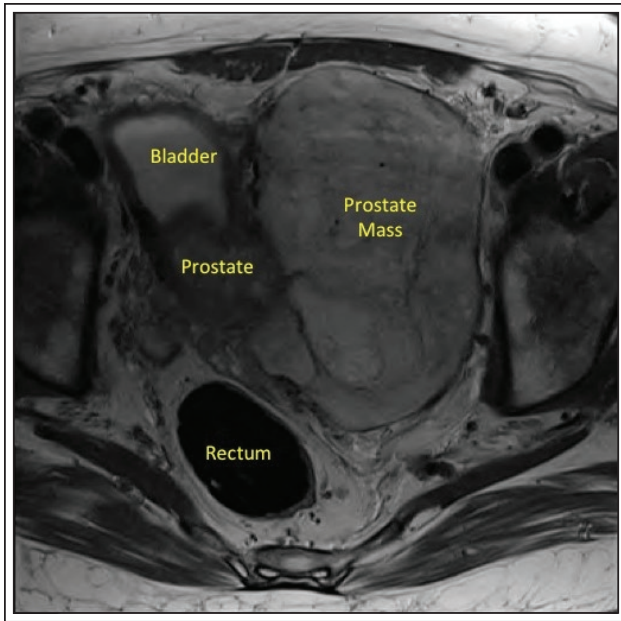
Magnetic resonance imaging of the pelvis showing a mass arising from the left side of the prostate and encroaching upon the bladder and left ureter.
